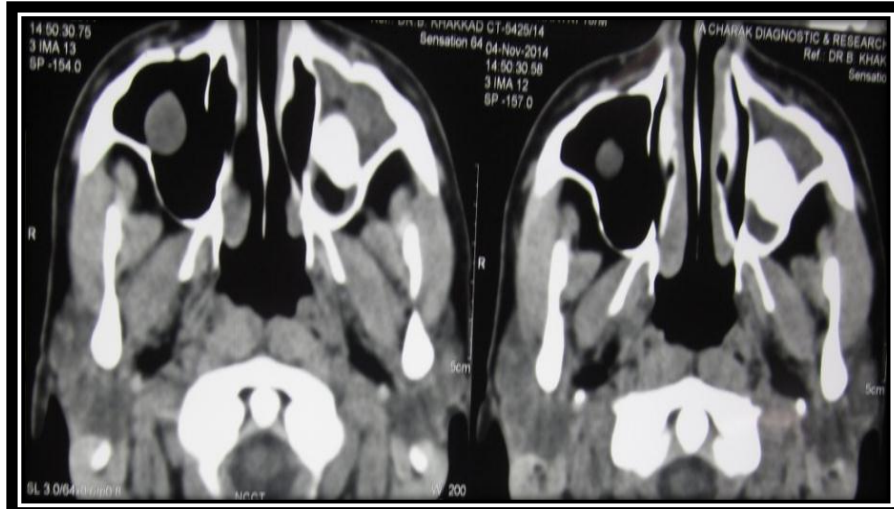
Axial section CT showing radiopacity reducing maxillary sinus cavity volume.
